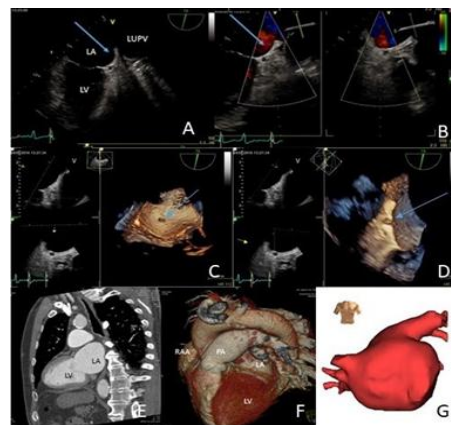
TEE images of the LA at mid oesophageal level: on 2D TEE images (angle 76 degrees) LAA was not visualized (arrows, panel A), even by Doppler (panel B); 3D TEE "en face" view demonstrated the absence of LAA anatomical orifice (panel C) and no LAA body was identified, only a small residue (panel D). CT images: 2 chambers view (panel E) and 3D volume rendered image (panel F) showed absence of LAA body, with a clear definition of the right atrial appendage. Anatomic reconstruction by Navx navigation system of the LA during cryoablation: anterior view (panel G) confirmed LAA body absence on LA outer surface. LA left atrium; LV left ventricle; RAA right atrial appendage; LUPV left upper pulmonary vein; PA pulmonary artery.
